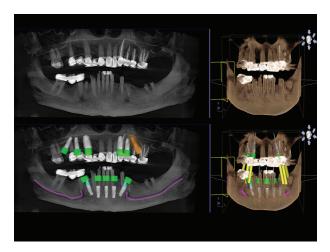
CBCT image and virtual implant plan
